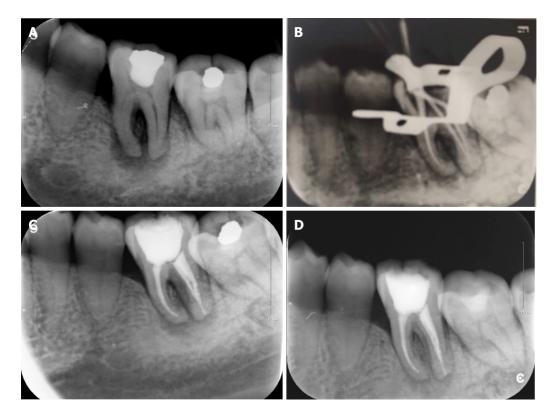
Periapical radiograph. A: Initial preoperative periapical radiograph; B: Gutta-Percha cone fitting and working length confirmation with periapical radiograph; C: Post-obturation periapical radiograph; D: Periapical radiograph at the 3 mo follow-up.
